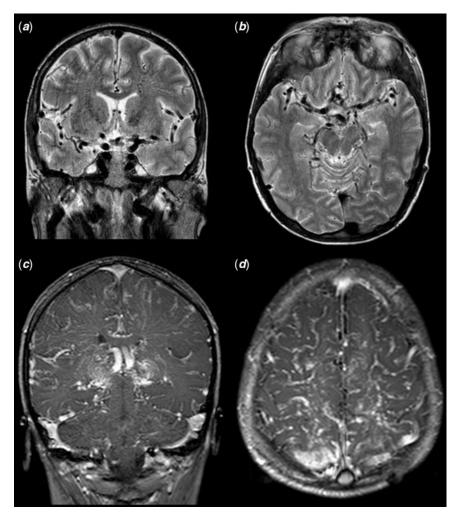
Intracranial vascular enlargement is seen in T2 weighted (a, b) and diffuse leptomeningeal contrast enhancement in T1 weighted (c, d) magnetic resonance images.
